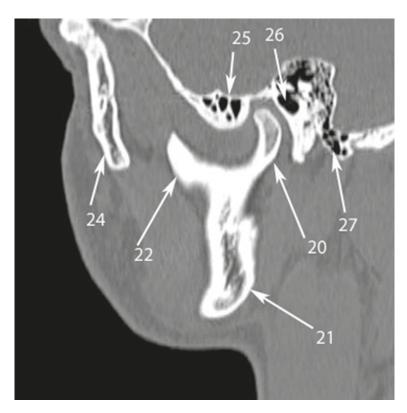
Sagittal CT scan at the level of mandibular ramus. Numbers with arrows denote the following anatomical structures: 20 – mandibular condyle; 21 – ramus of the mandibule; 22 – coronoid process; 23 – the beginning of the mandibular canal (near the mandibular foramen); 24 – zygomatic bone; 25 – temporal bone.
